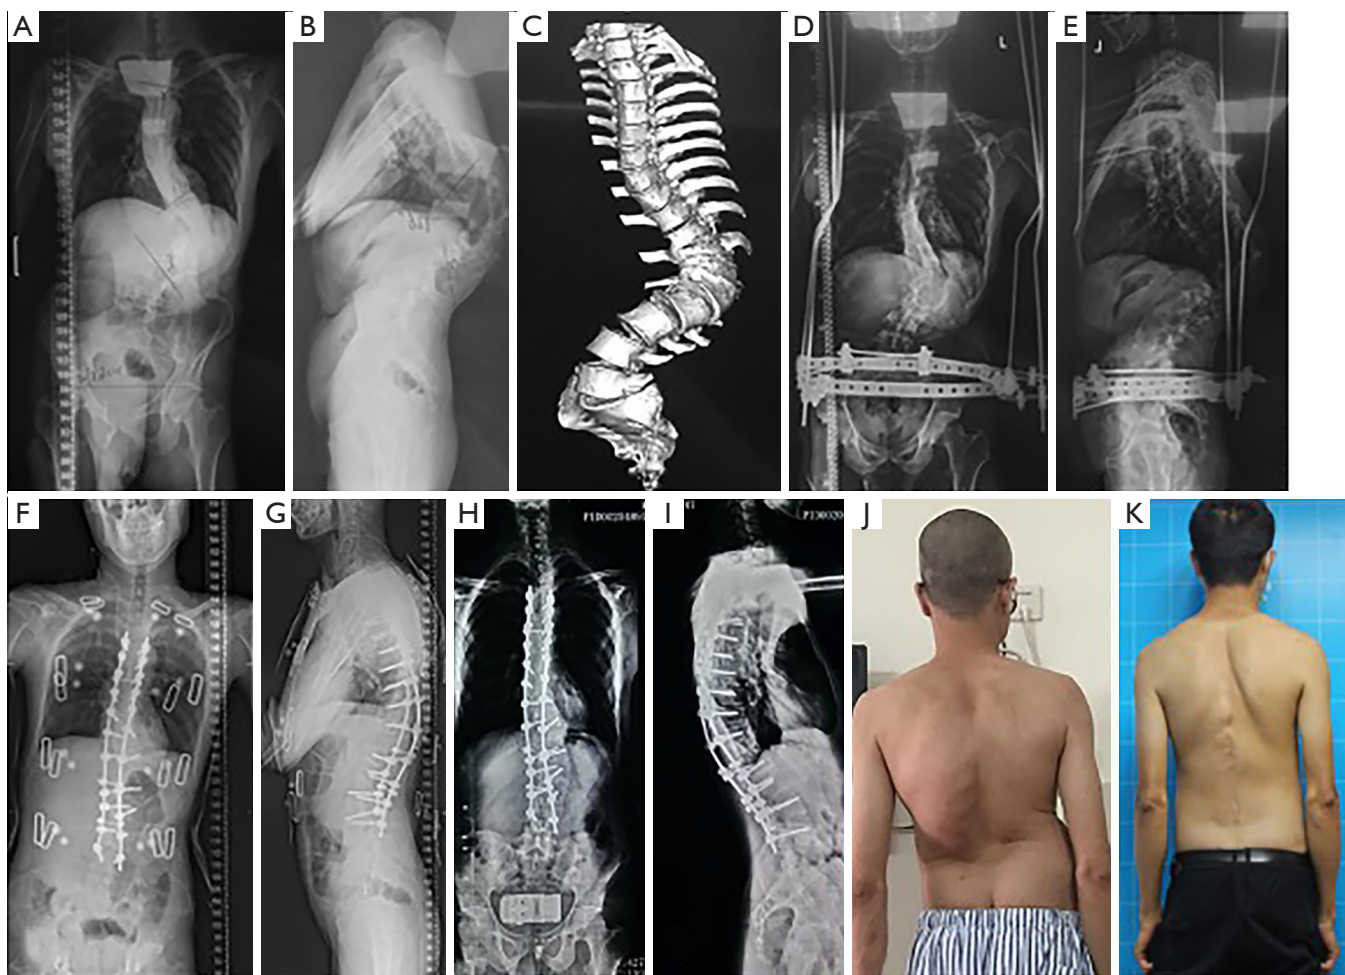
A patient with angular-like severe spinal deformities underwent presurgical halo-pelvic traction and type 3 bone-disc-bone osteotomy. Preoperative X-rays showed that the thoracolumbar scoliosis angle was 95° and the kyphosis angle was 125° (A-B). Preoperative computed tomography is also shown (C). After traction, the Cobb angles of scoliosis and kyphosis decreased to 65° and 110° , respectively (D,E). After surgery, the coronal and sagittal profiles were corrected (F,G) and maintained well during the 3-year follow-up (H,I). The pictures of the patient's back appearance showed excellent improvement (J,K).
